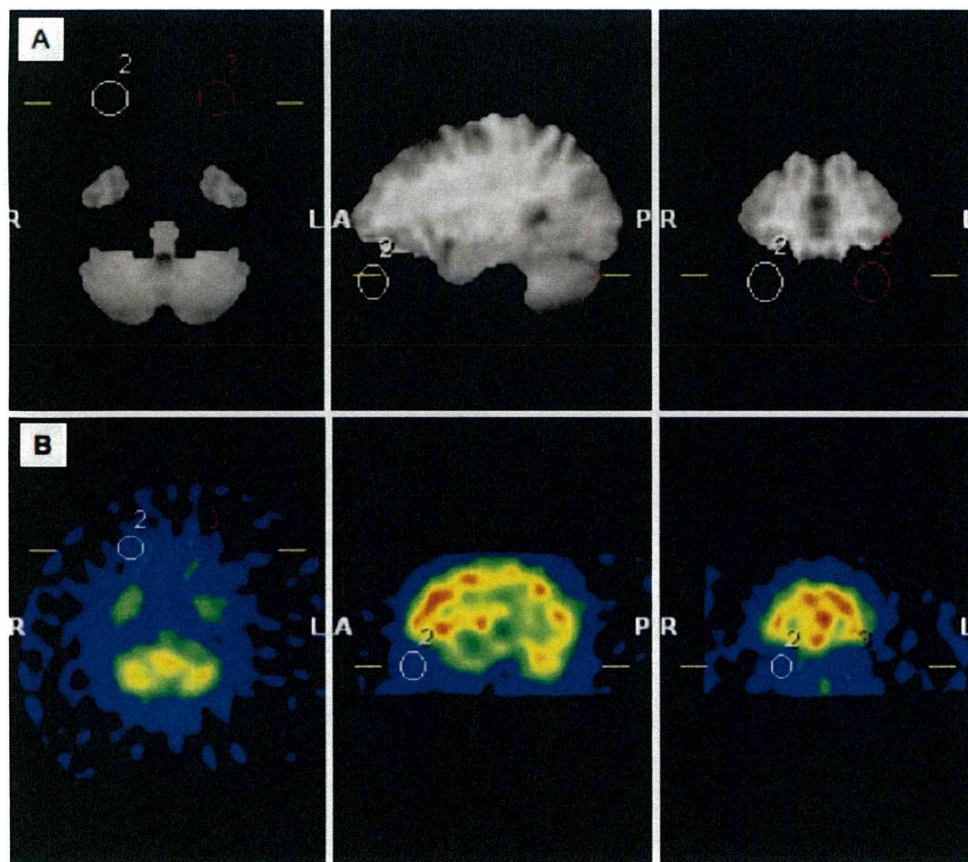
A Three-dimensional region of interest (3D-ROI) template drawn on a normalized brain magnetic resonance imaging scan. B The same template adjusted by Fusion Viewer to a 3D-volume *N*-isopropyl-*p*-[¹²³I]-iodoamphetamine (I-123 IMP), which was also standardized by Neurostat software.
